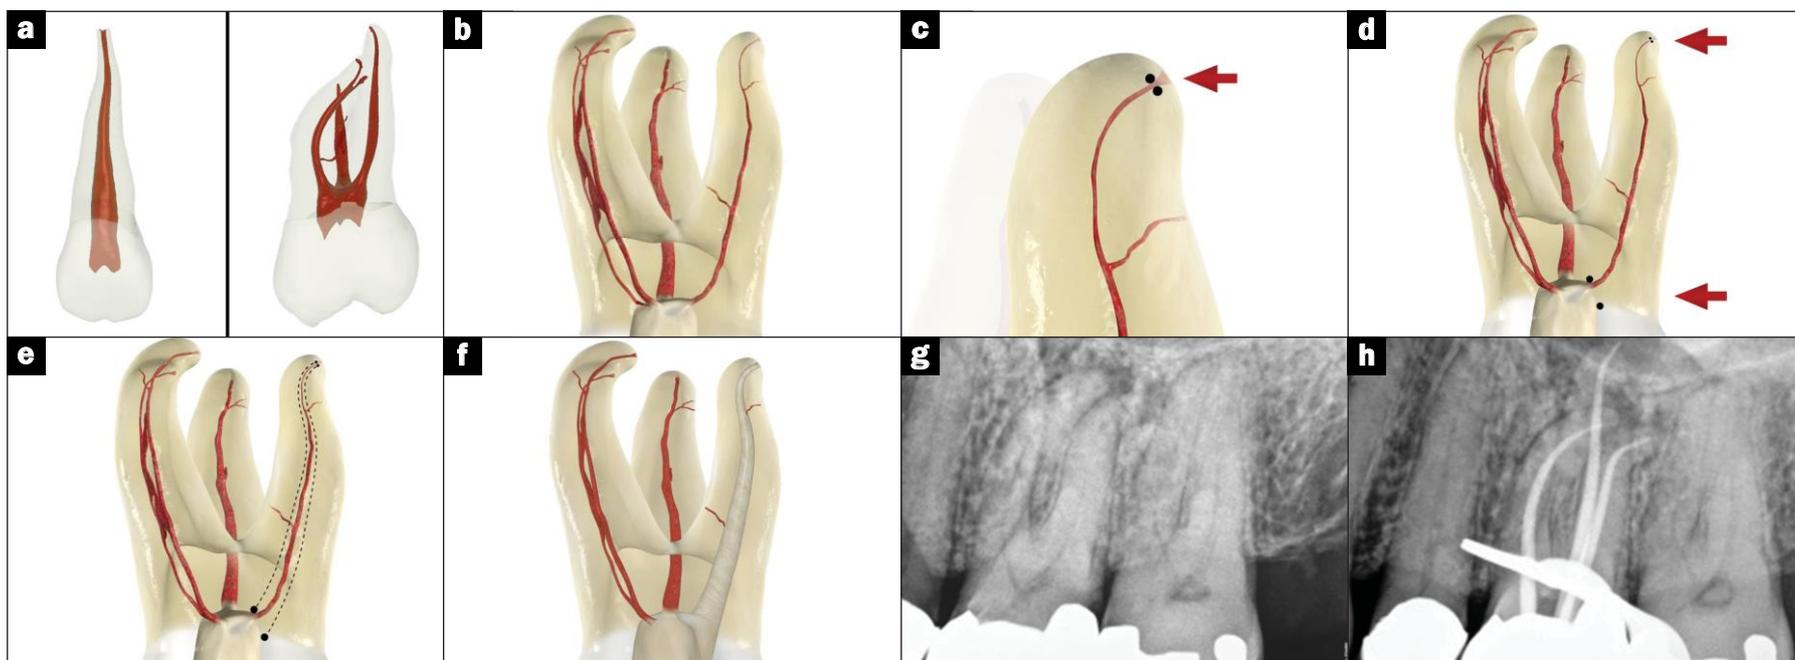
(a) Note: ToothAtlas.com reveals natural width of central is about a third the width of the root while the DB canal of the maxillary molar is about one fifth the width of the root. The shaping width goal of endodontics is simply to give nature back her original dimensions. I call this “Maximally Appropriate Endodontics.” The ferrule location that matters is not even mesial-distal; it is buccal-lingual. Shaping width claims of various Ni-Ti systems should be evaluating CBCT buccal and lingual remaining tooth; not mesial-distal! (b) Animation of aging or calcifying DB canal that needs to be shaped to between one fifth to one third the width of the coronal portion of the canal. (c) Arrow points to the 2 apical dots that represent the minimal physiologic constriction. (d) Appropriate coronal PTG shaping width indicated by dots need to be connected with the apical dots for proper funnel-shaped canal. (e) Dots connected demonstrating outline of desired “maximally appropriate” funnel shape. (f) Animated proper DB shape. (g) Pretreatment of maxillary left first molar. (h) Three “Maximally Appropriate” cone fits. (Figures 3b to 3f courtesy of Advanced Endodontics.)
